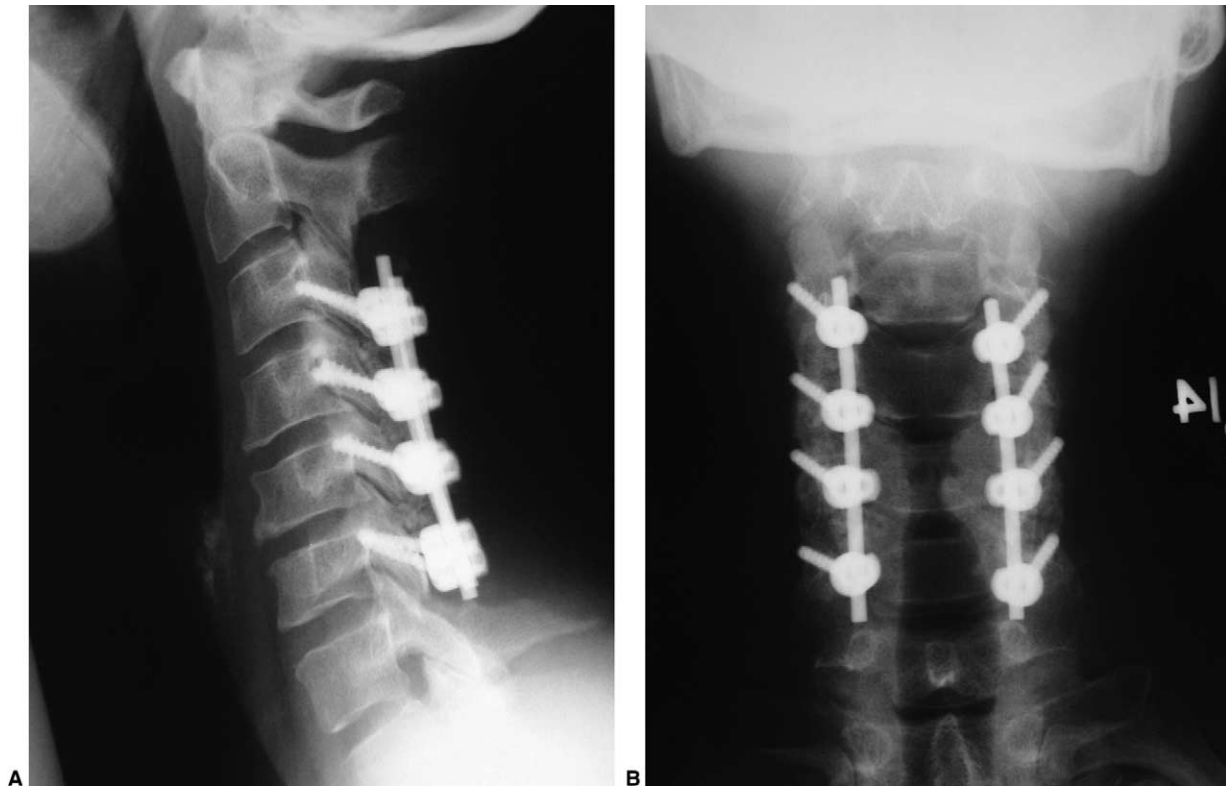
Postoperative lateral (A) and anterior-posterior (B) X-rays of the cervical spine of the patient from Fig. 1 showing typical placement of the lateral mass screws with a solid fusion posteriorly.
